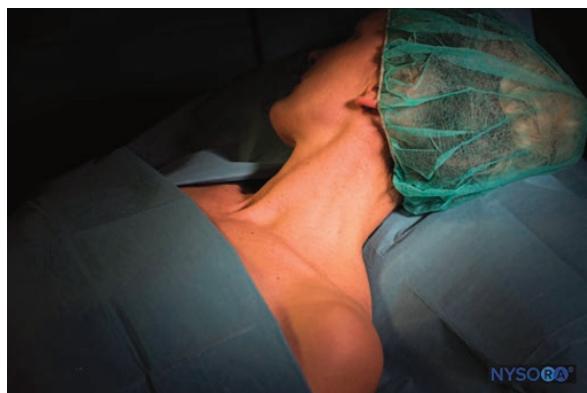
Ideal patient position for an ultrasound-guided interscalene brachial plexus block.
